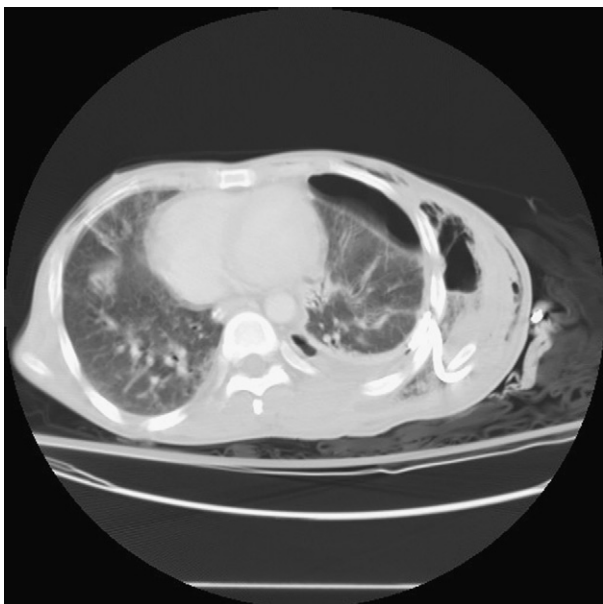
Chest computed tomography revealed bilateral infiltration, left pleural thickening with enhancement, hydro-pneumothorax and extensive soft tissue “gas formation.”
